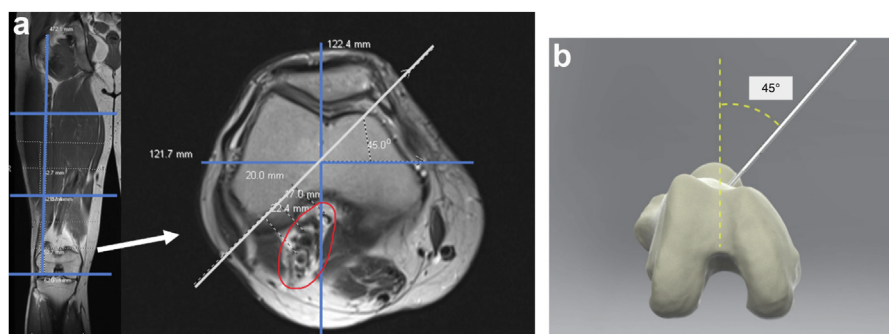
Coronal MRI of right femur with corresponding scout mode axial MRI with neurovascular structures measured from projected femoral pin at 45° (a) and correlating intraoperative image of femoral array in insertion (b). MRI, magnetic resonance imaging.
